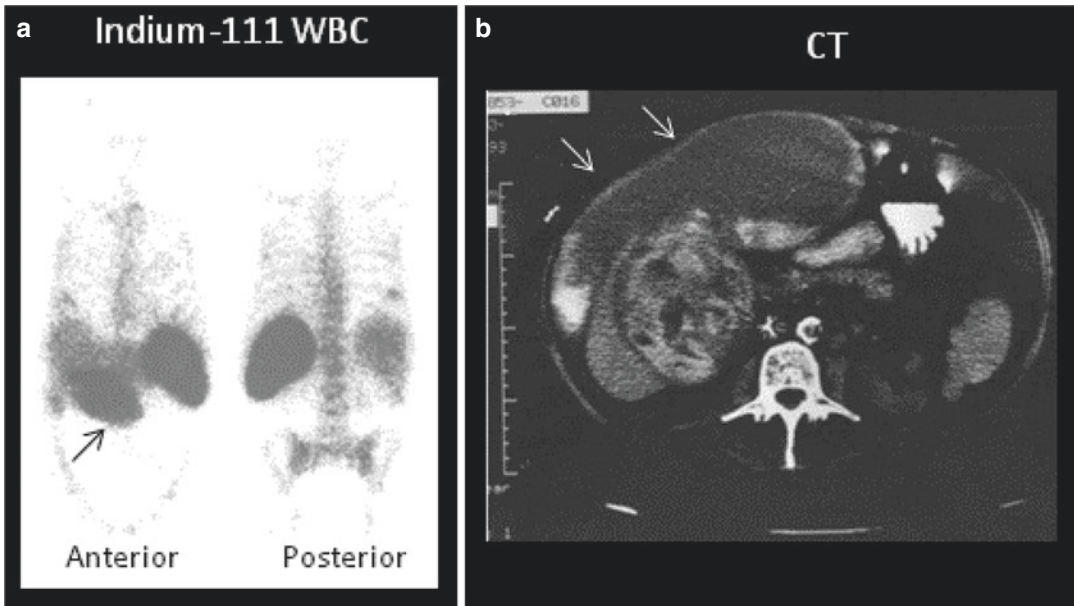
(a, b) ^{111}In -labeled leukocyte study (a) shows a large acute abdominal abscess (arrow) corresponding to the finding (arrows) on CT (b)
